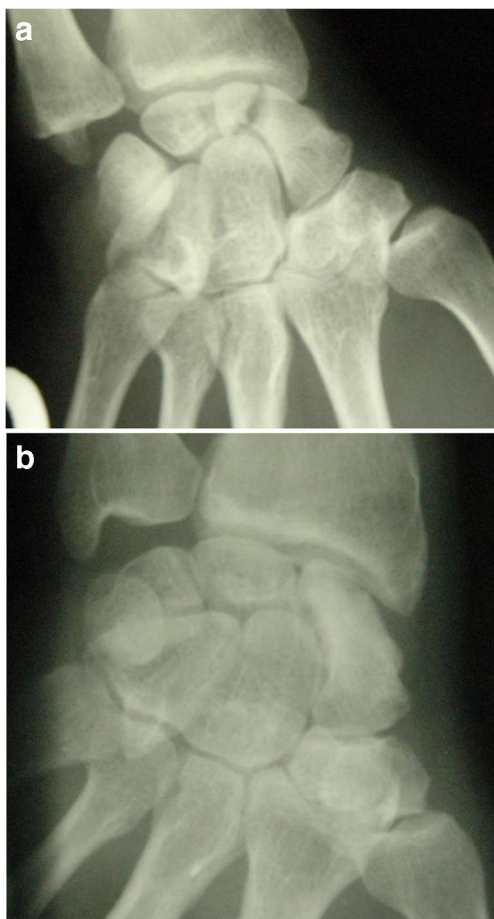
a Pre-operative radiograph SNU treated with xenograft. b Postoperative radiograph SNU treated with xenograft
